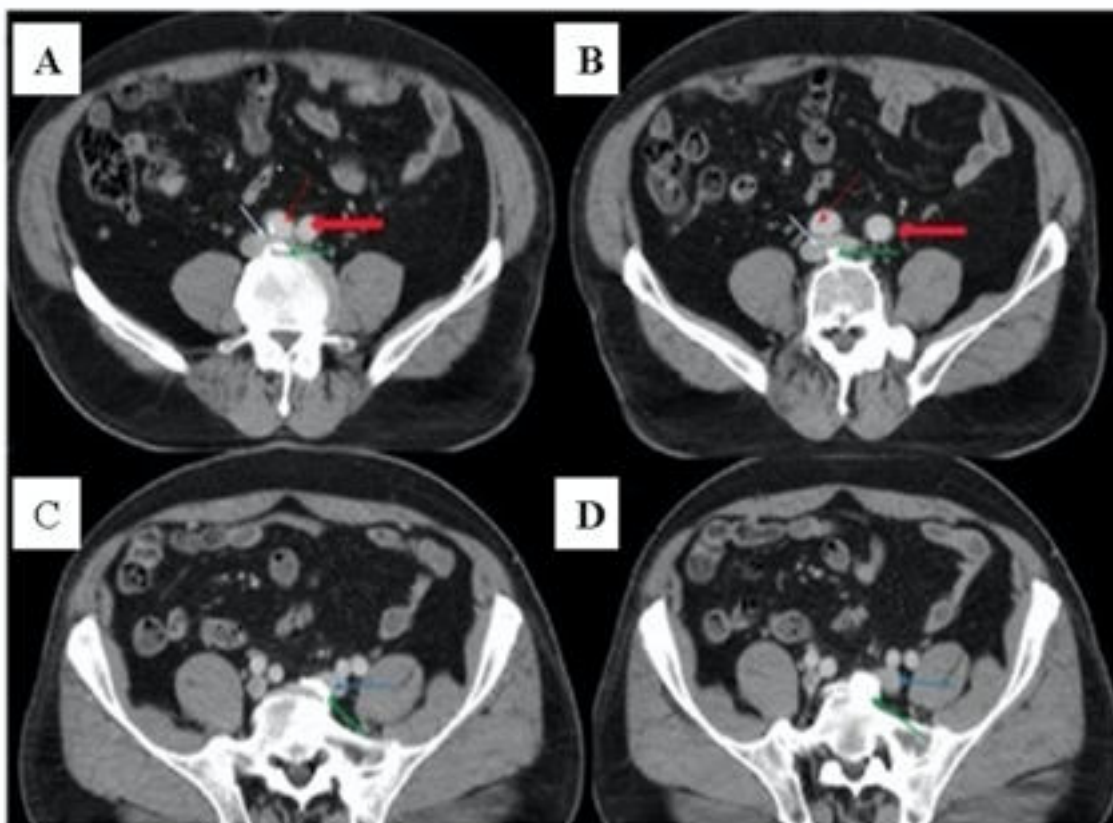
(A, B, C, D) Computed tomographic angiographic images of compressing common iliac vein by the vertebral osteophyte (Yellow arrow: vertebral osteophyte, Light blue arrow: vena cava inferior bifurcation, Blue arrow: left common iliac vein, Thick red arrow: left common iliac artery, Thin red arrow: right common iliac artery).
